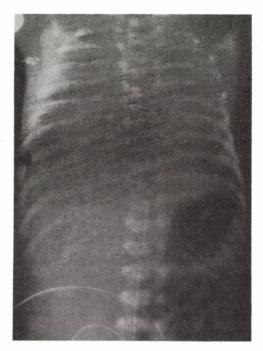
L.I. boy. Gestation period: 28 weeks. Birth weight: 1200 g. (Patient No.4. of Table II/B). The chest X-ray shows the radiological signs of stage IV according to Giedion (Görgényi). Did not receive Curosurf treatment.
